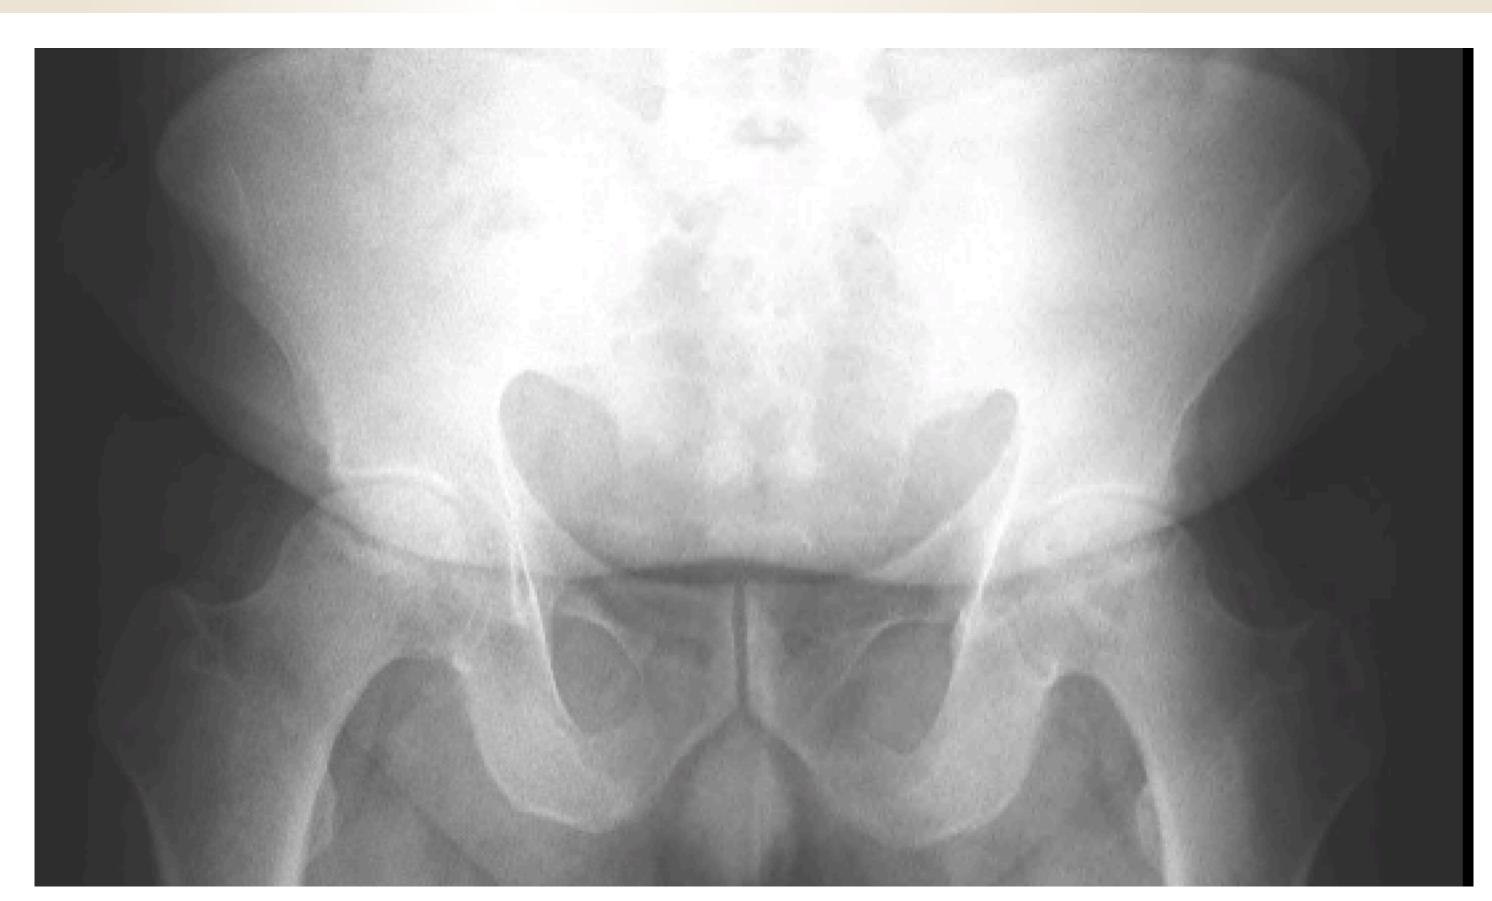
AP Radiograph revealing advance osteonecrosis of each femoral head with collapse of the articular bone bilaterally
